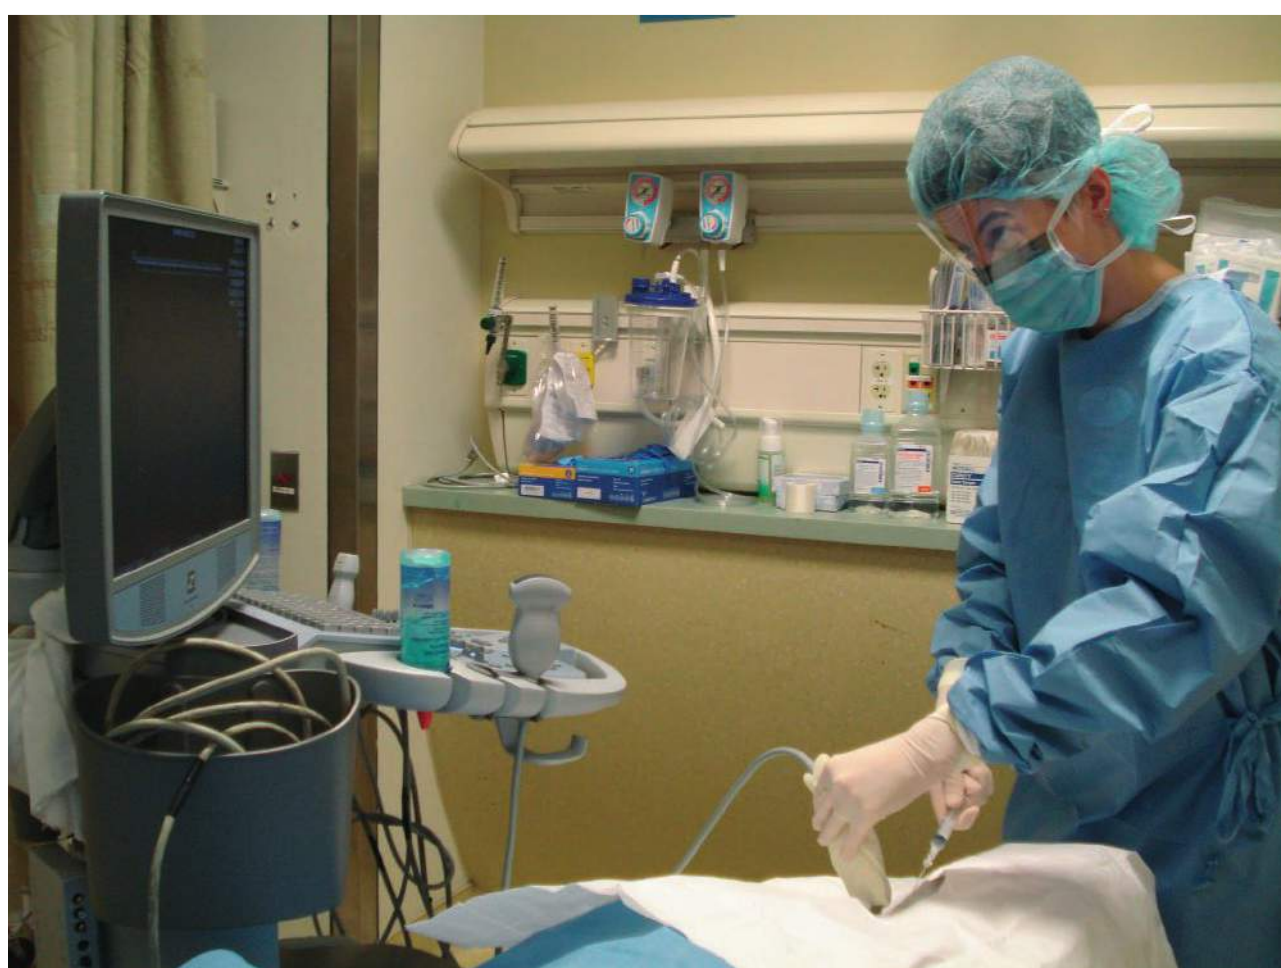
Optimal relationship between practitioner, patient, and ultrasound machine. Note the machine is in the same line of sight as the patient.
